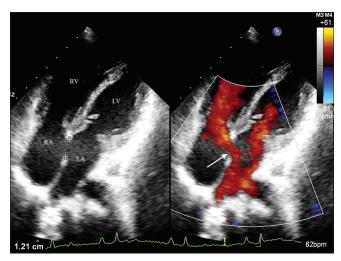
Two-dimensional echocardiography (apical four-chamber view with color compare) showing 12.1 mm ostium secundum atrial septal defect with left to right shunt
